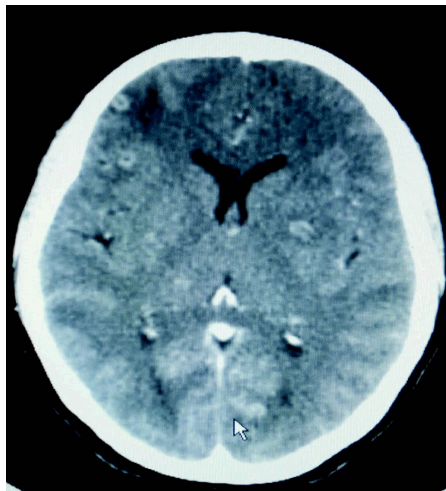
CT scan picture showing diffuse parenchymatous neurocysticercosis in the form of with largest lesion measuring 7.7×9 mm.
